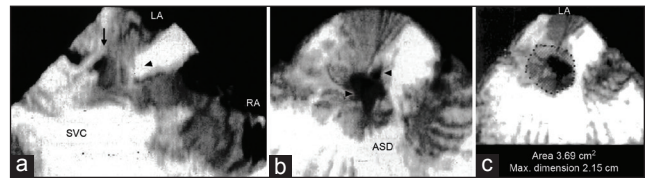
(a-c) Multiplane three-dimensional transesophageal echocardiographic reconstruction of sinus venosus ASD. (a) The arrowhead points to the large defect in the superior portion of the atrial septum. The arrow shows the right superior pulmonary vein entering the SVC-atrial junction at the site of the defect. (b and c) Orthogonal views demonstrating the size of the defect (ASD), which measured 3.69 cm² in area. The maximal dimension of the defect was 2.15 cm, which corresponded to the diameter of 2 cm measured at surgery. The top arrowhead in B points to the right superior pulmonary vein, and the bottom arrowhead points to the defect. (ASD: Atrial septal defect; SVC: Superior vena cava; LA: Left atrium; RA: Right atrium). Reproduced with permission from Nanda NC, Ansingkar K, Espinal M, et al. Transesophageal three-dimensional echo assessment of sinus venosus ASD. *Echocardiography* 1999;16:835-7
